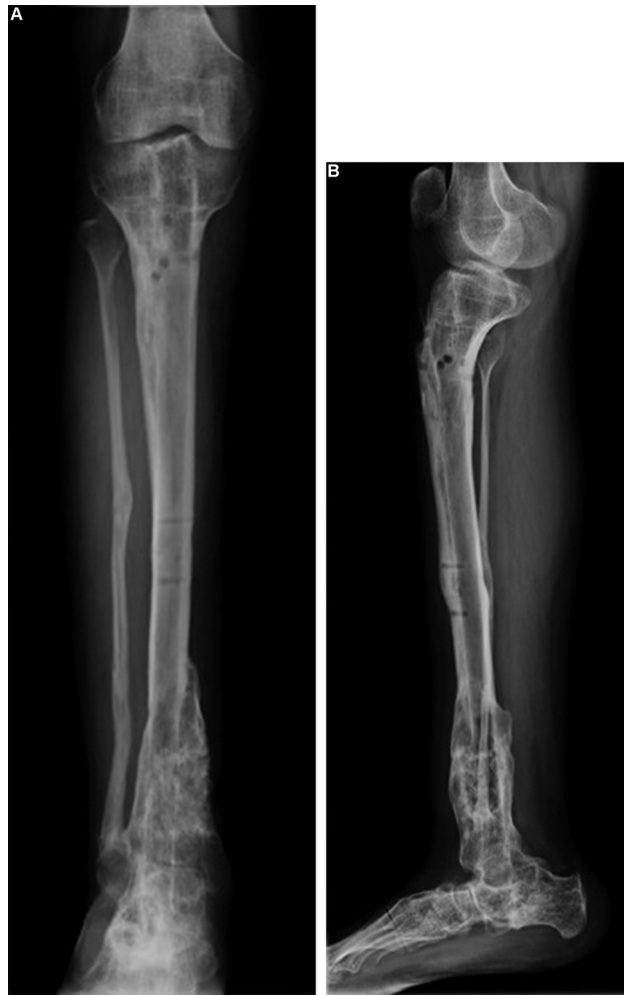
Radiograph obtained 2 years after the last surgical procedure; bone healing is complete, and the tibial slope is 26°.
